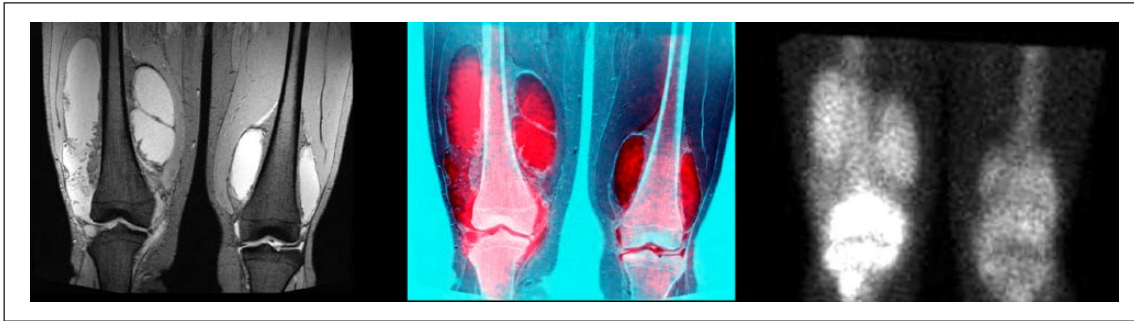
Coronal T2*-weighted gradient-echo image (left) and planar ^{99m}Tc MDP (right). In the center, for visualization purposes, the MR image is represented in inverted color scale, with the red channel of the RGB image substituted by the MDP image.
